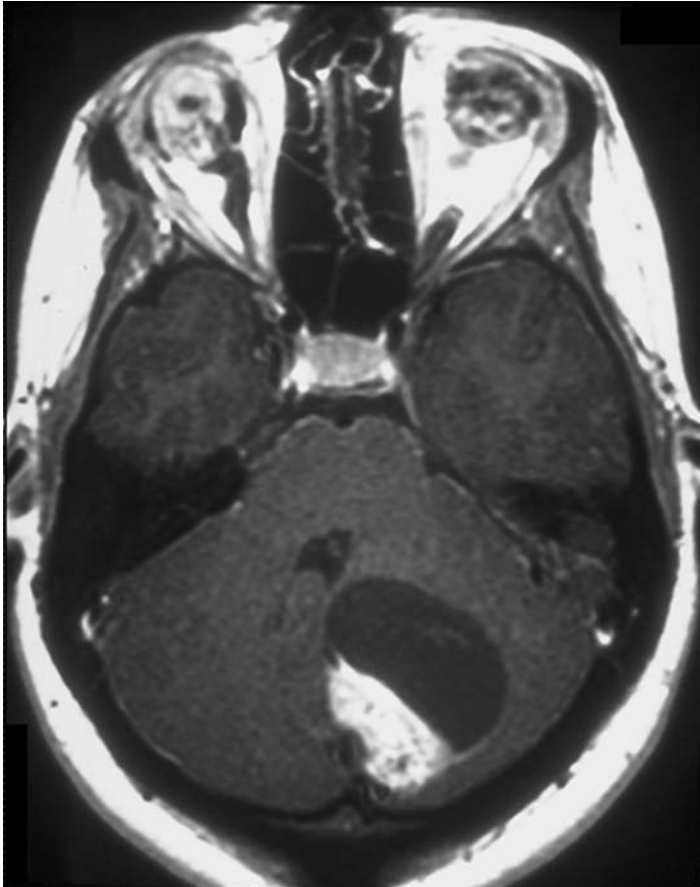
MRI in a patient with von Hippel–Lindau syndrome who is clinically blind. Scan demonstrates a left-sided hemangioblastoma with both cystic and solid components. Note that bilateral retinal angiomas are present in both eyes, a further manifestation of VHL.
